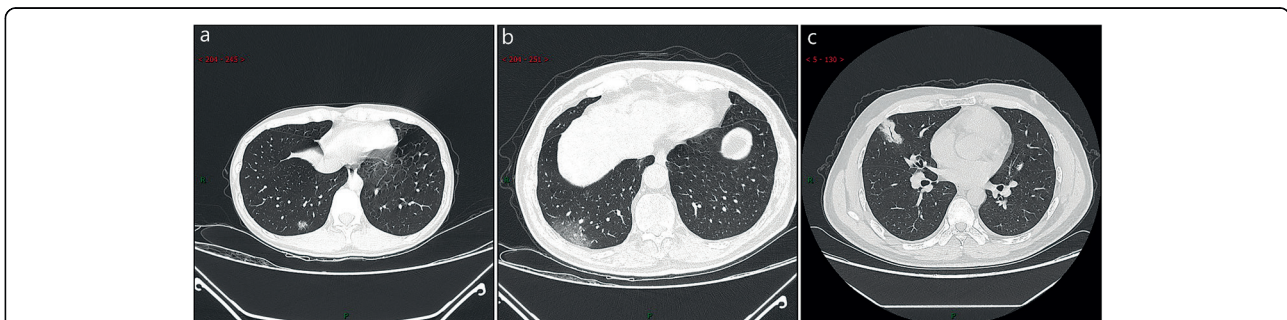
CT imaging of ultra-early stage. a A 33 years old female with patchy ground-glass opacities after occupational exposure. b A 67 years old male with a history of contact with infected patients, showing large ground-glass opacity. c A 35 years old female exhibiting large consolidated opacity with air-bronchogram inside after occupational exposure
